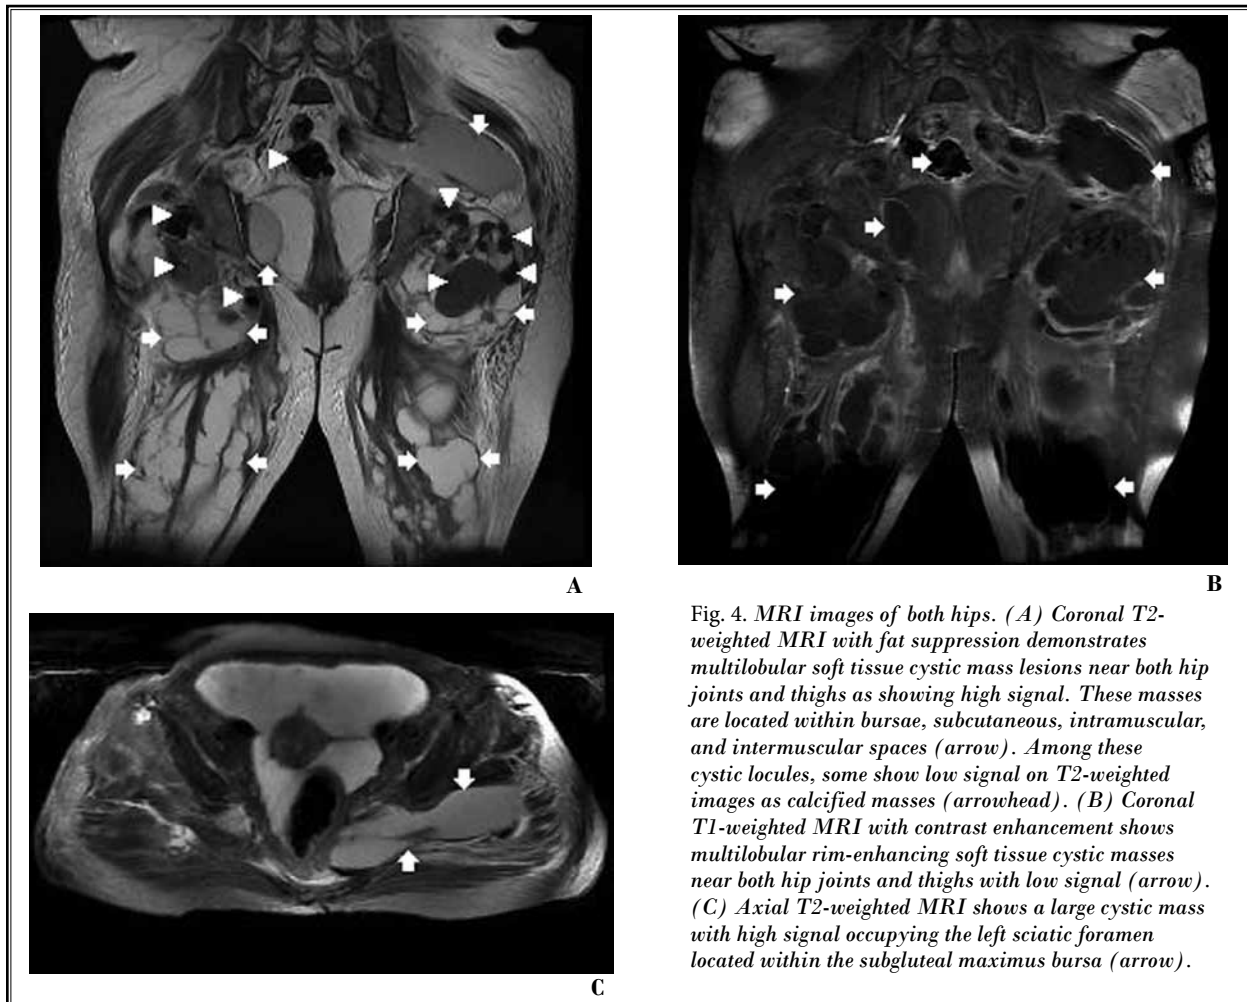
MRI images of both hips. (A) Coronal T2-weighted MRI with fat suppression demonstrates multilobular soft tissue cystic mass lesions near both hip joints and thighs as showing high signal. These masses are located within bursae, subcutaneous, intramuscular, and intermuscular spaces (arrow). Among these cystic locules, some show low signal on T2-weighted images as calcified masses (arrowhead). (B) Coronal T1-weighted MRI with contrast enhancement shows multilobular rim-enhancing soft tissue cystic masses near both hip joints and thighs with low signal (arrow). (C) Axial T2-weighted MRI shows a large cystic mass with high signal occupying the left sciatic foramen located within the subgluteal maximus bursa (arrow).
